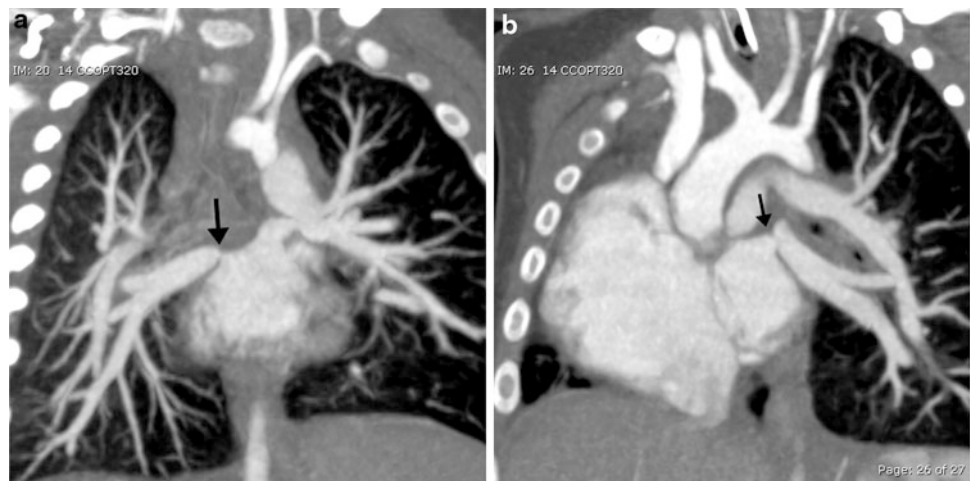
Repaired tetralogy of Fallot status post pulmonary valve replacement with recurrent bacterial endocarditis. Oblique coronal CT images (a, b) demonstrate hypodense clot (arrow) making obtuse angle with the vessel wall in the descending branch of the RPA consistent with chronic pulmonary embolism
